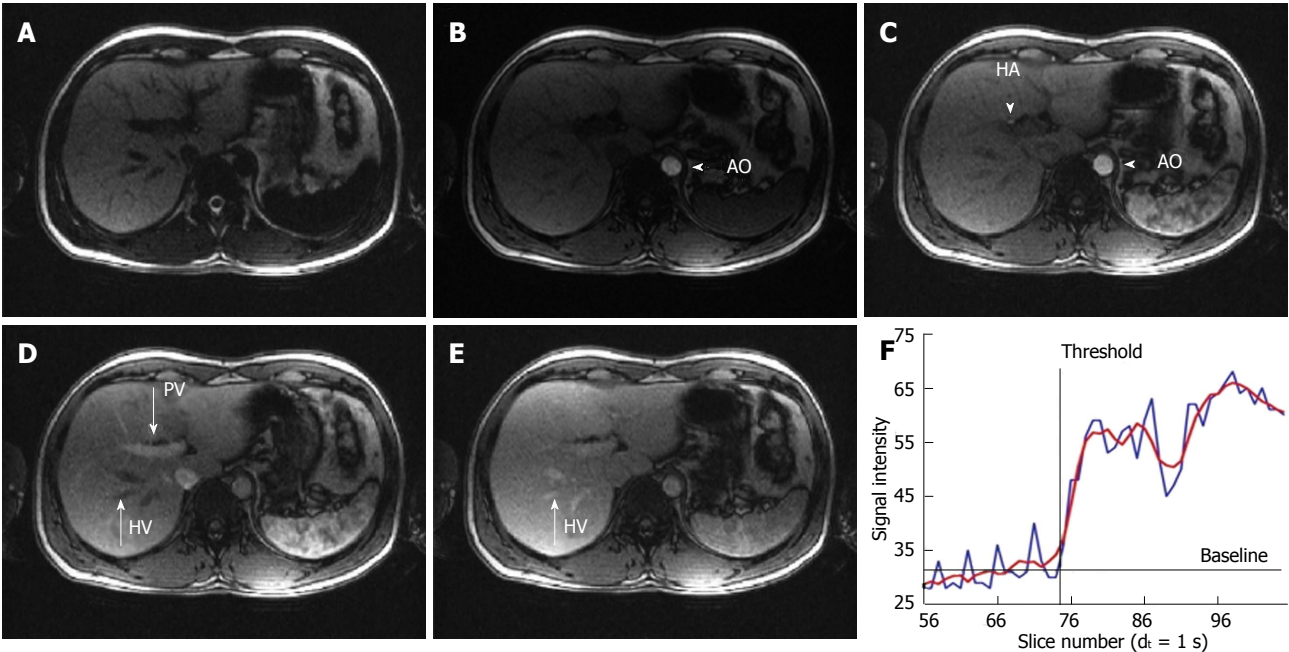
Magnetic resonance imaging images of the T1-weighted sequence for hepatic transit time analysis at different time points. A: Baseline image without contrast; B: Arterial phase with opacification of the aorta (AO); C: Arterial phase with opacification of the AO and the hepatic artery (HA); D: Portal venous phase with additional enhancement of the portal vein (PV); Note that the hepatic veins (HV) are still not enhanced; E: Venous phase with complete opacification of all vessels including the HV; F: Example of a typical time intensity curve acquired from a ROI placed at the position of the HA; The raw data in the graph (blue line) has a modulation due to patient breathing. Therefore the curve has to be fitted and smoothed (red line). The calculated baseline as well as threshold point, demonstrating the arrival time of the contrast agent is drawn.
